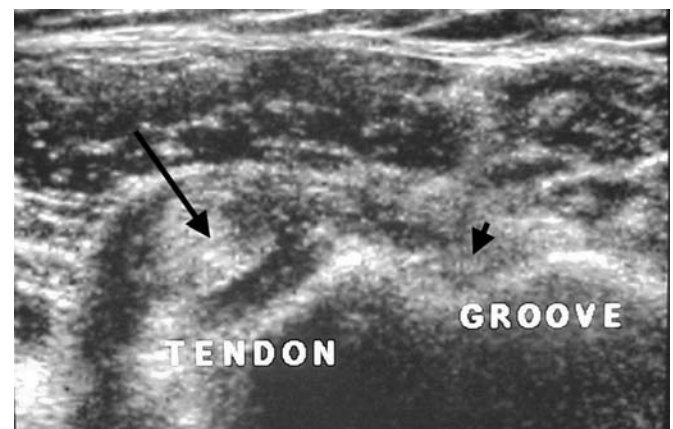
Transverse ultrasound of the left bicipital groove. The groove is empty (short arrow) and the tendon dislocated medially (long arrow).
